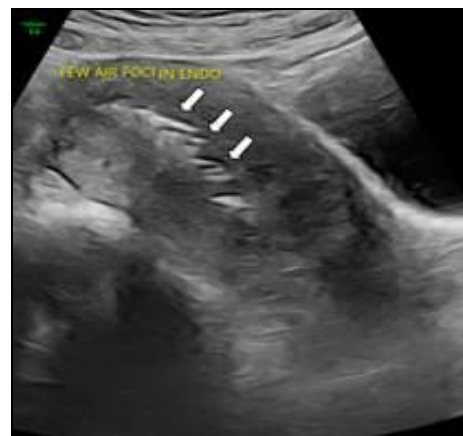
Mid-sagittal ultrasonography of the uterus reveals intraluminal echogenic foci within the endometrial cavity demonstrating dirty acoustic shadowing, consistent with the presence of intrauterine air.
